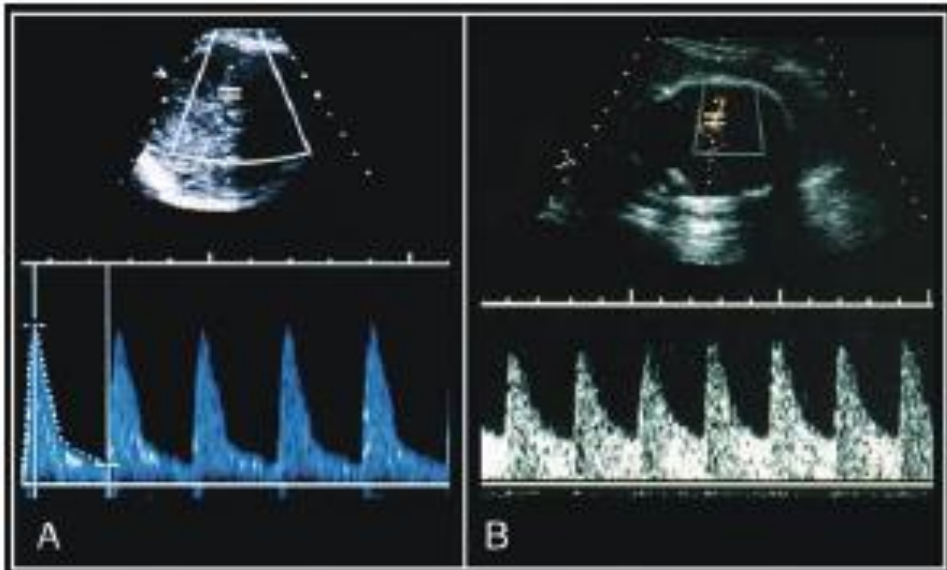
Doppler waveform of middle cerebral artery in normal fetus (A) and in a hypoxemic fetus (B) .
